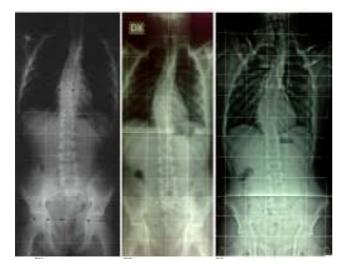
Spinal X-ray at the age of 6 (a), 10 (b) and 16 (c) years respectively: showing the mildly progressive dorsal convex right scoliosis.
